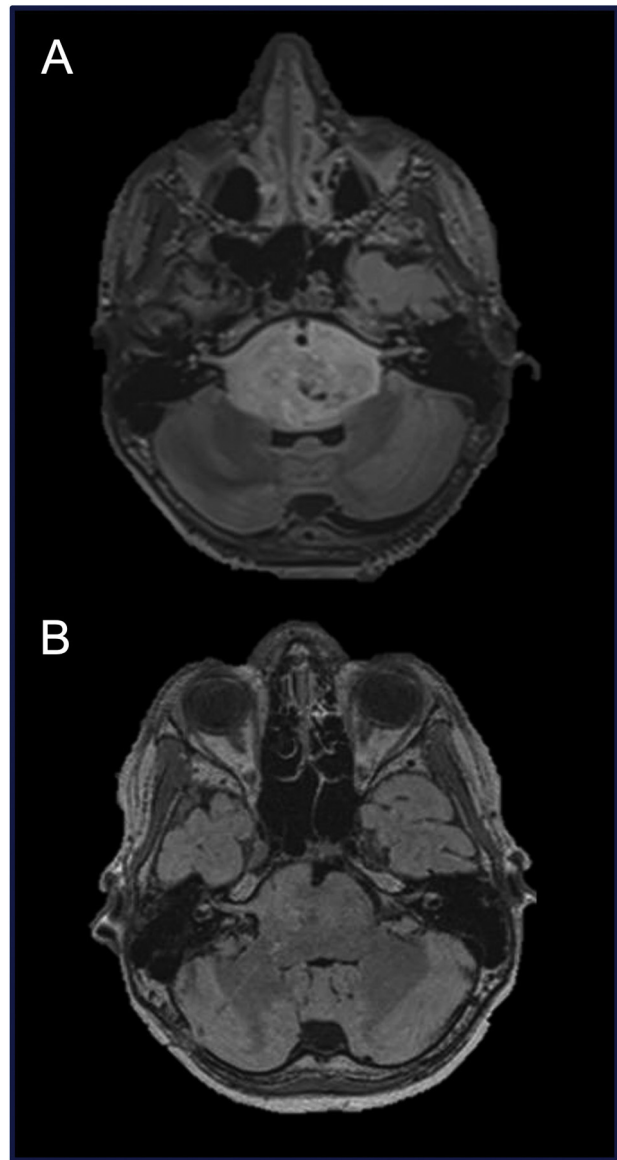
Example of tumor area reduction on magnetic resonance imaging (MRI). Axial FLAIR MRI before (A) and 3 months after (B) Delta-24-RGD administration and completion of radiotherapy.
